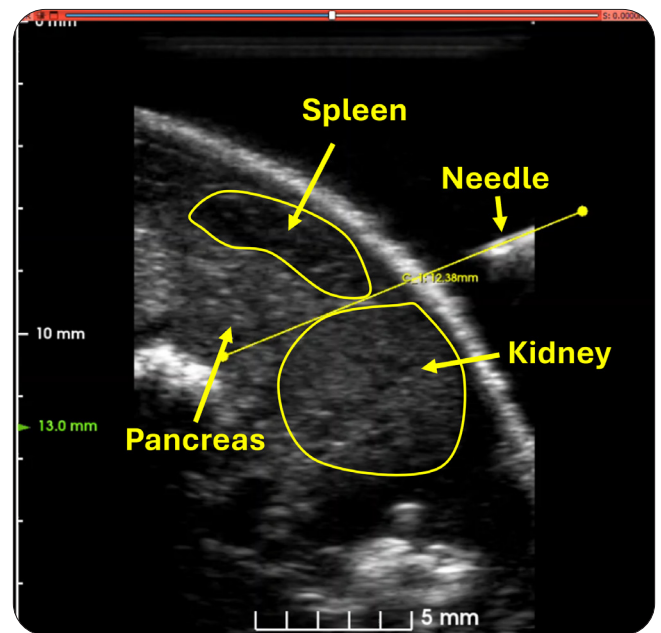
Ultrasound view of the pancreas and surrounding organs when using the recommended positioning.
